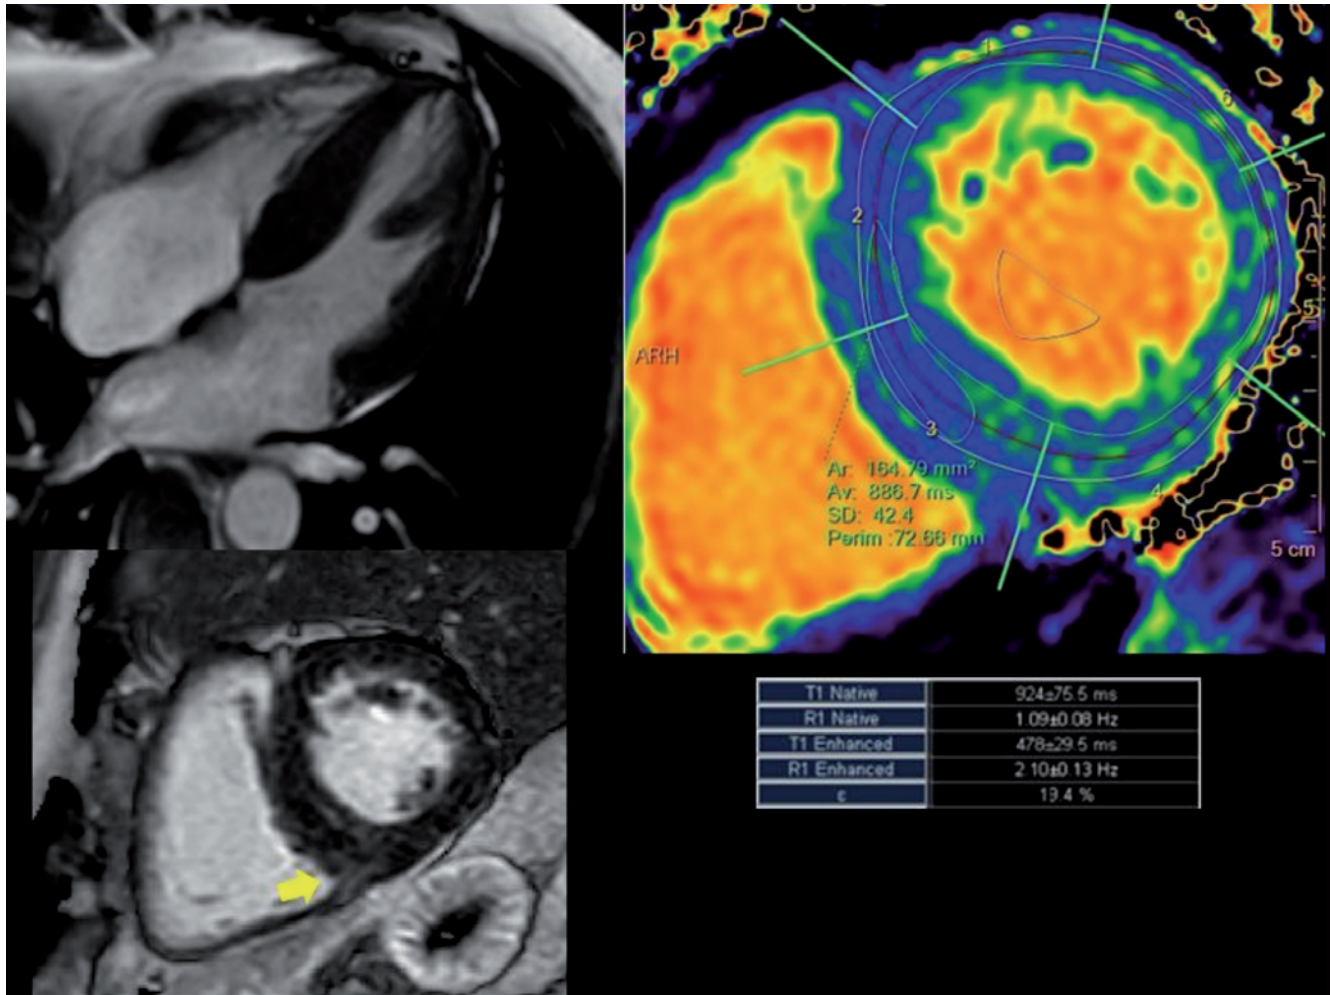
Cardiac magnetic resonance images with native T1 mapping. The yellow arrow indicates intramiocardial fibrosis.
